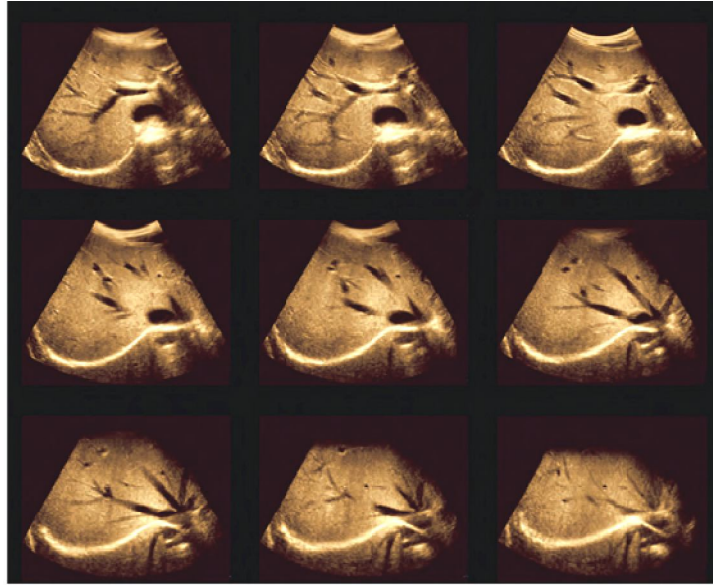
Ultrasound images show normal liver. (Tuma 2013).
